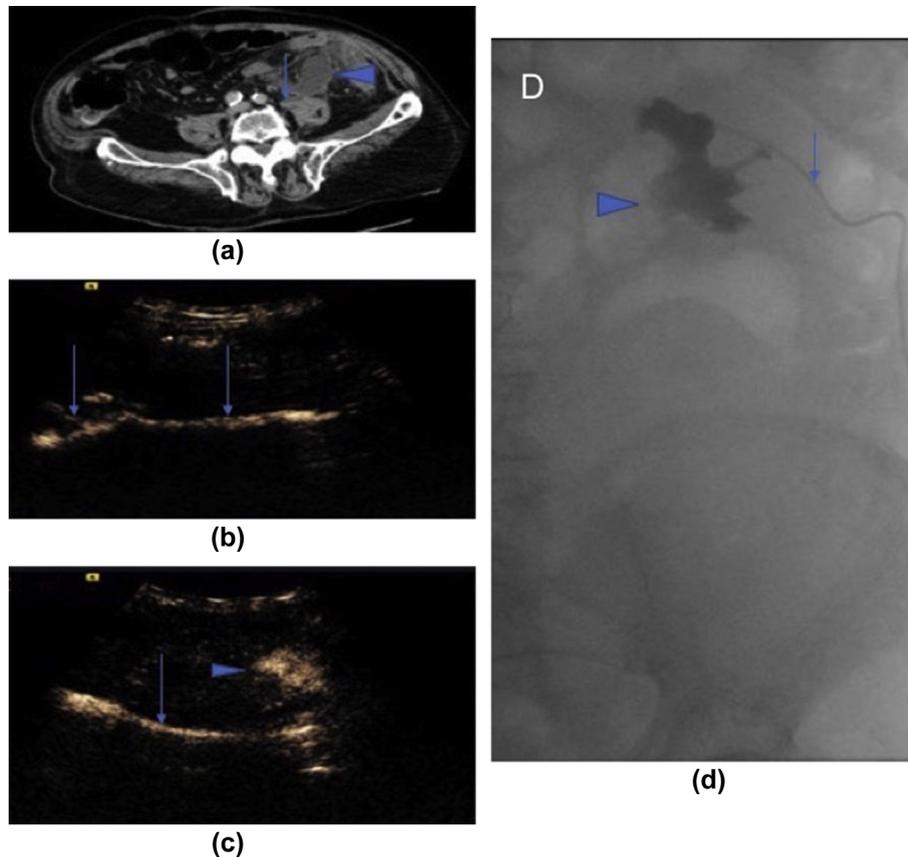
CT, CEUS nephrostogram, and fluoroscopic nephrostogram all performed within a 24-hour period with interval nephrostomy insertion post-CT for a ureteric leak. (a) Venous CT demonstrates a fluid collection (arrowhead) associated with the distal left ureter (arrow). After insertion of a nephrostomy CEUS nephrostogram was performed (b,c), which showed filling of the renal pelvis, proximal and mid ureter (arrows), but also showed pooling of contrast medium within a collection (arrowhead). (d) Fluoroscopic nephrostogram via the nephrostomy (arrow) showed filling of the renal pelvis (arrowhead), but no drainage into the ureter, bladder, or known urinoma.
